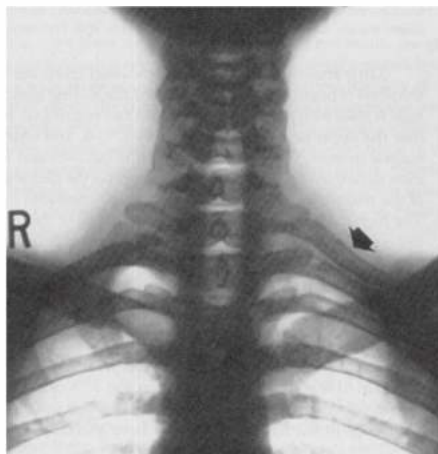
• Chest x-ray demonstrating left cervical rib (arrow).
